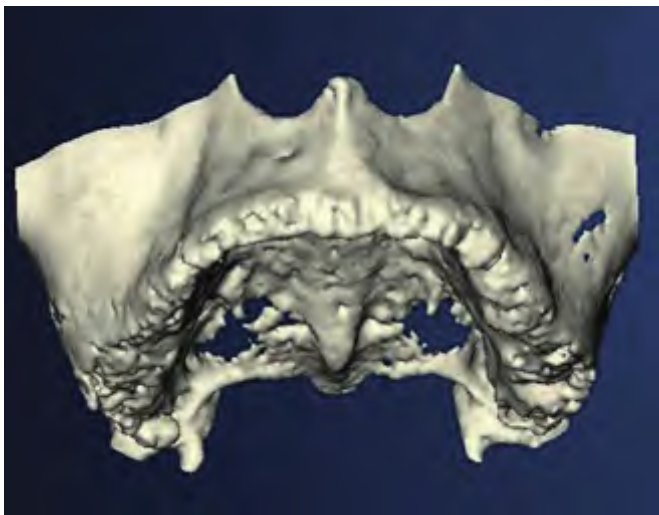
This is a reformatted computed tomography image of one patient's edentulous maxillae. Note the detail relative to the topography of the edentulous jaw.
